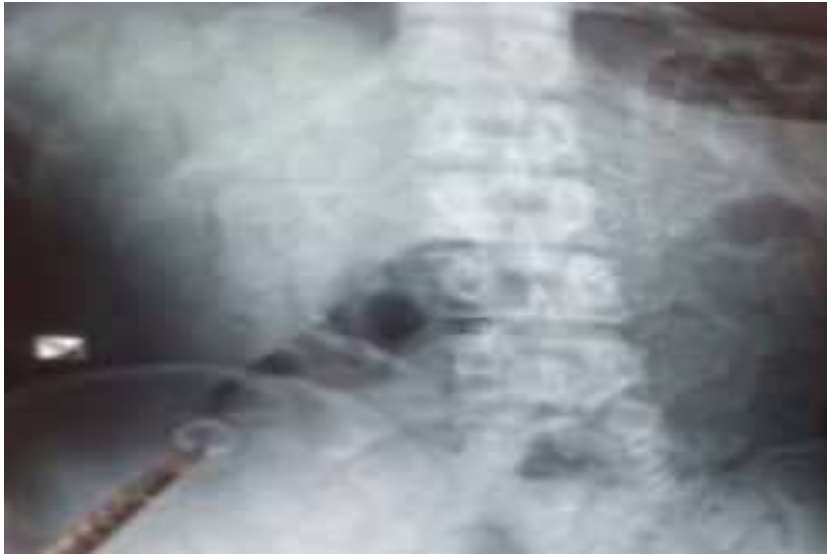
X-ray image showing stercolitis.
